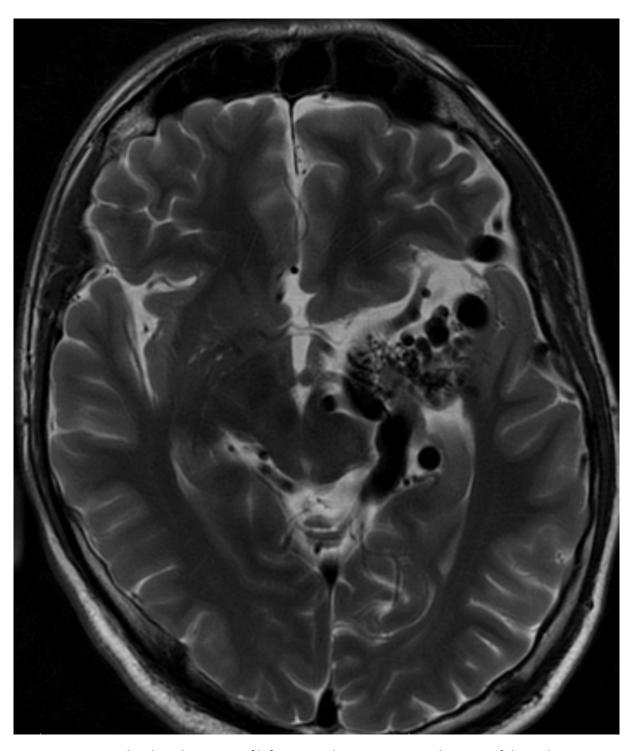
T2-weighted axial MR scan of left temporal AVM SM IV, involvement of deep eloquent areas.
